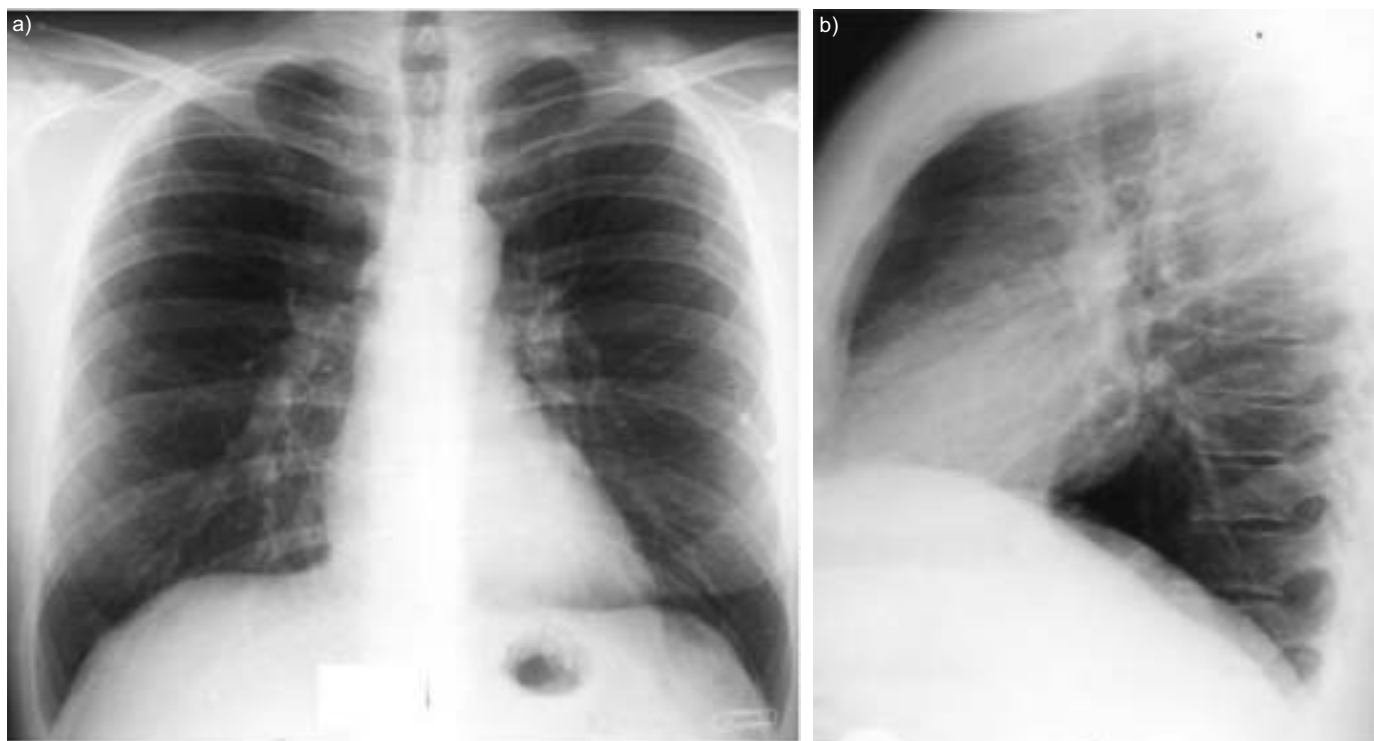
Chest radiograph showing a) posterior-anterior view and b) lateral view.
